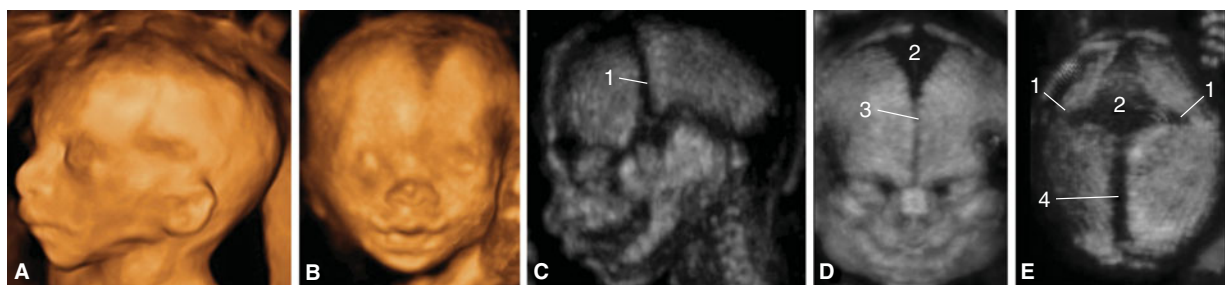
Three-dimensional (3D) sonographic examination of the fetal face at midgestation. (A), (B) Surface rendering from a lateral and frontal perspective. (C)–(E) Maximum rendering demonstrating the skull and the sutures and fontanels interposed among the different bones (1, coronal suture; 2, bregmatic fontanelle; 3, metopic or frontal suture; 4, sagittal suture). (Reproduced, with permission, from Piliu G. *Atlas of Obstetric Ultrasound*, The Global Library of Women's Medicine, www.glowm.com.)
